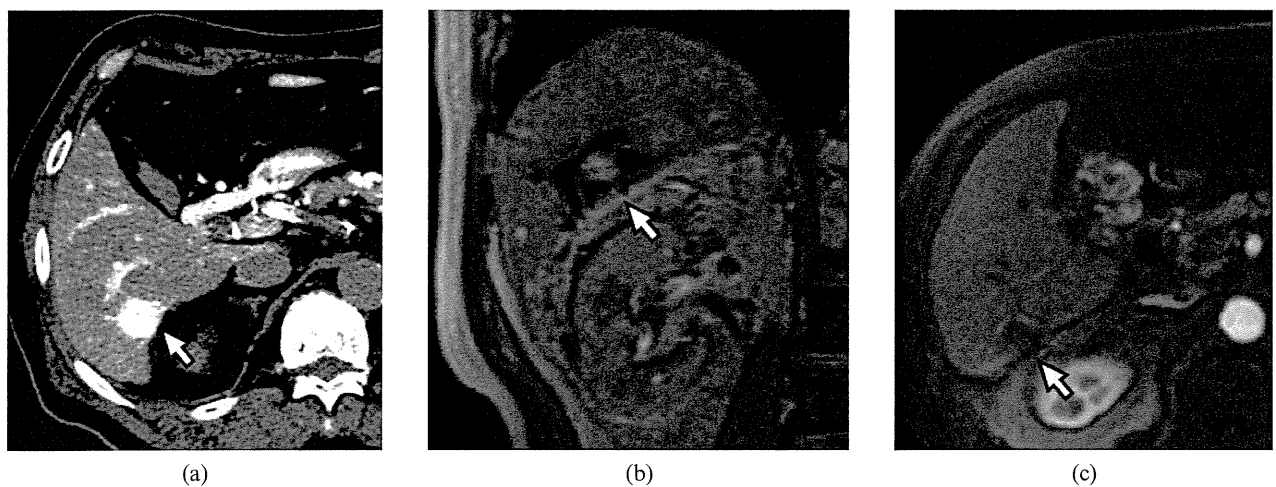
A 71-year-old male with a 21 mm hepatocellular carcinoma in liver segment VI. (a) Enhanced CT (arterial phase) reveals a hypervascular tumour (arrow). (b) Post-ablational MRI (coronal plane) reveals interruption of the rim at the liver surface (arrow). This tumour was evaluated as margin zero. (c) Enhanced MRI (arterial phase) 1 month after radiofrequency ablation reveals no hypervascular area (arrow). This tumour was evaluated as having no residue with insufficient ablative margin.
